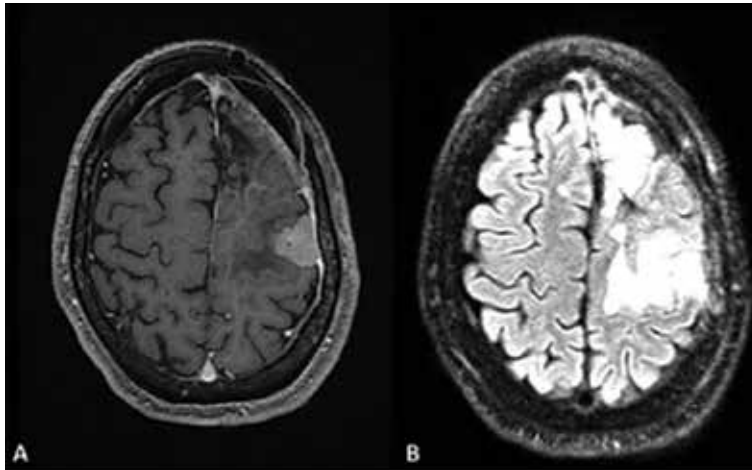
One-year-follow-up. (A) MRI. Axial post-gadolinium-DTPA T1-weighted gradient echo (FSPGR). (B) Flair sequences evidencing tumor recurrence adjacent to previous resection with the same features of original tumor.
